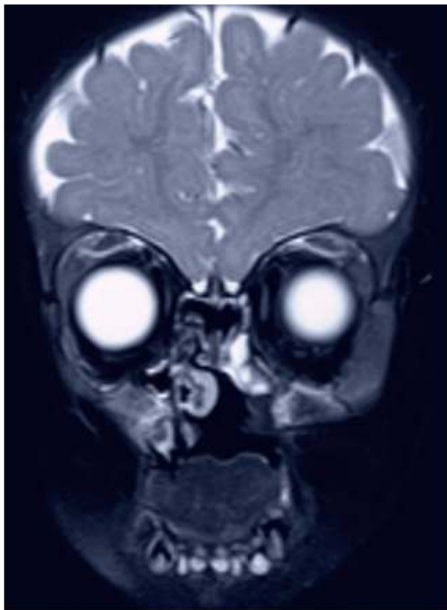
MRI of face, palate and skull showing necrotic and eroded palate and nasal septum. Hyperintensities in the surrounding bones show evidence of active osteomyelitis. No involvement of orbit and cerebral structures
